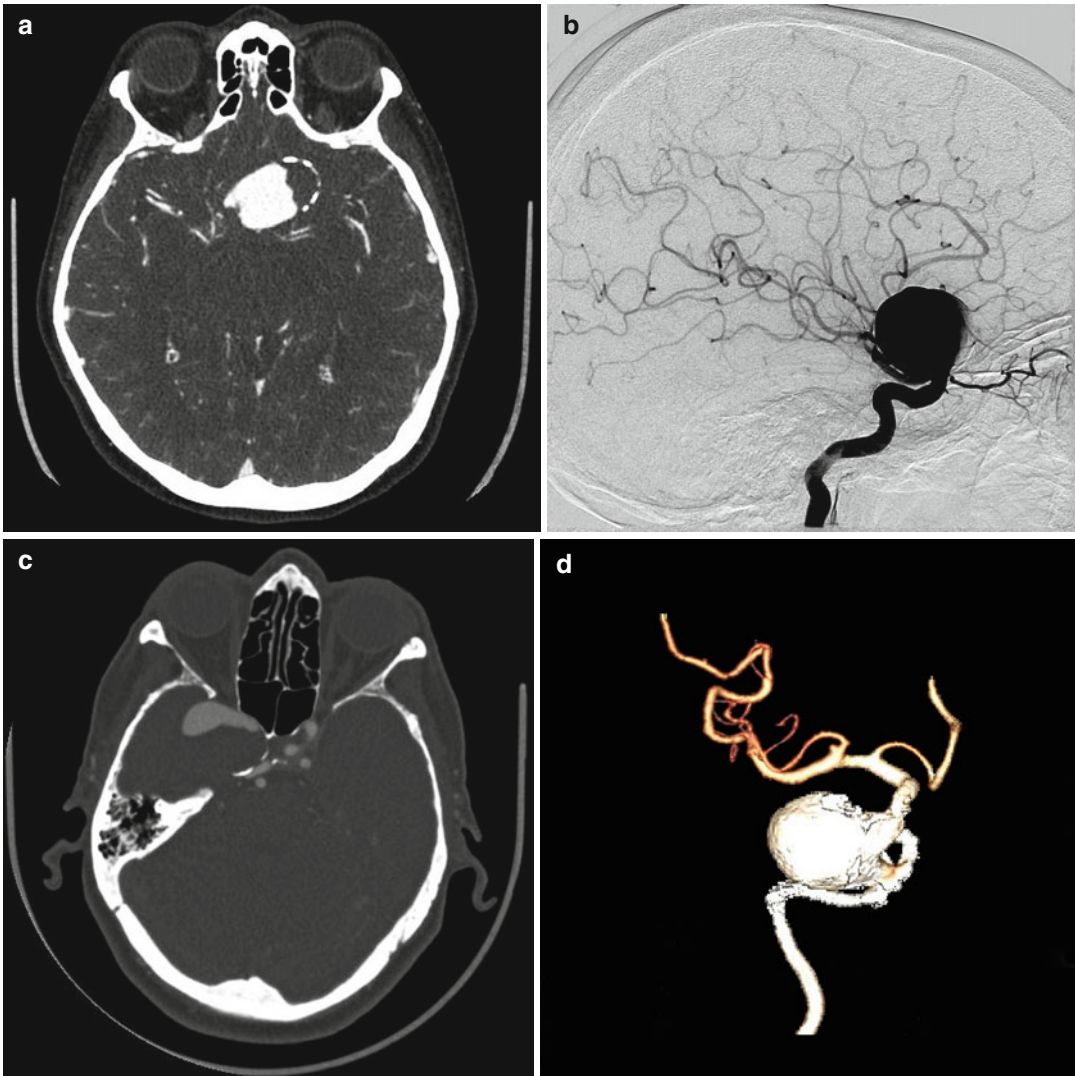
(a) Angio-CT: left giant supradiaphragmatic aneurysm. The true lumen of the aneurysm is appreciated after contrast administration. (b) Carotid angiography demonstrates the giant supradiaphragmatic aneurysm corresponding to a superior hypophysial artery aneurysm.
